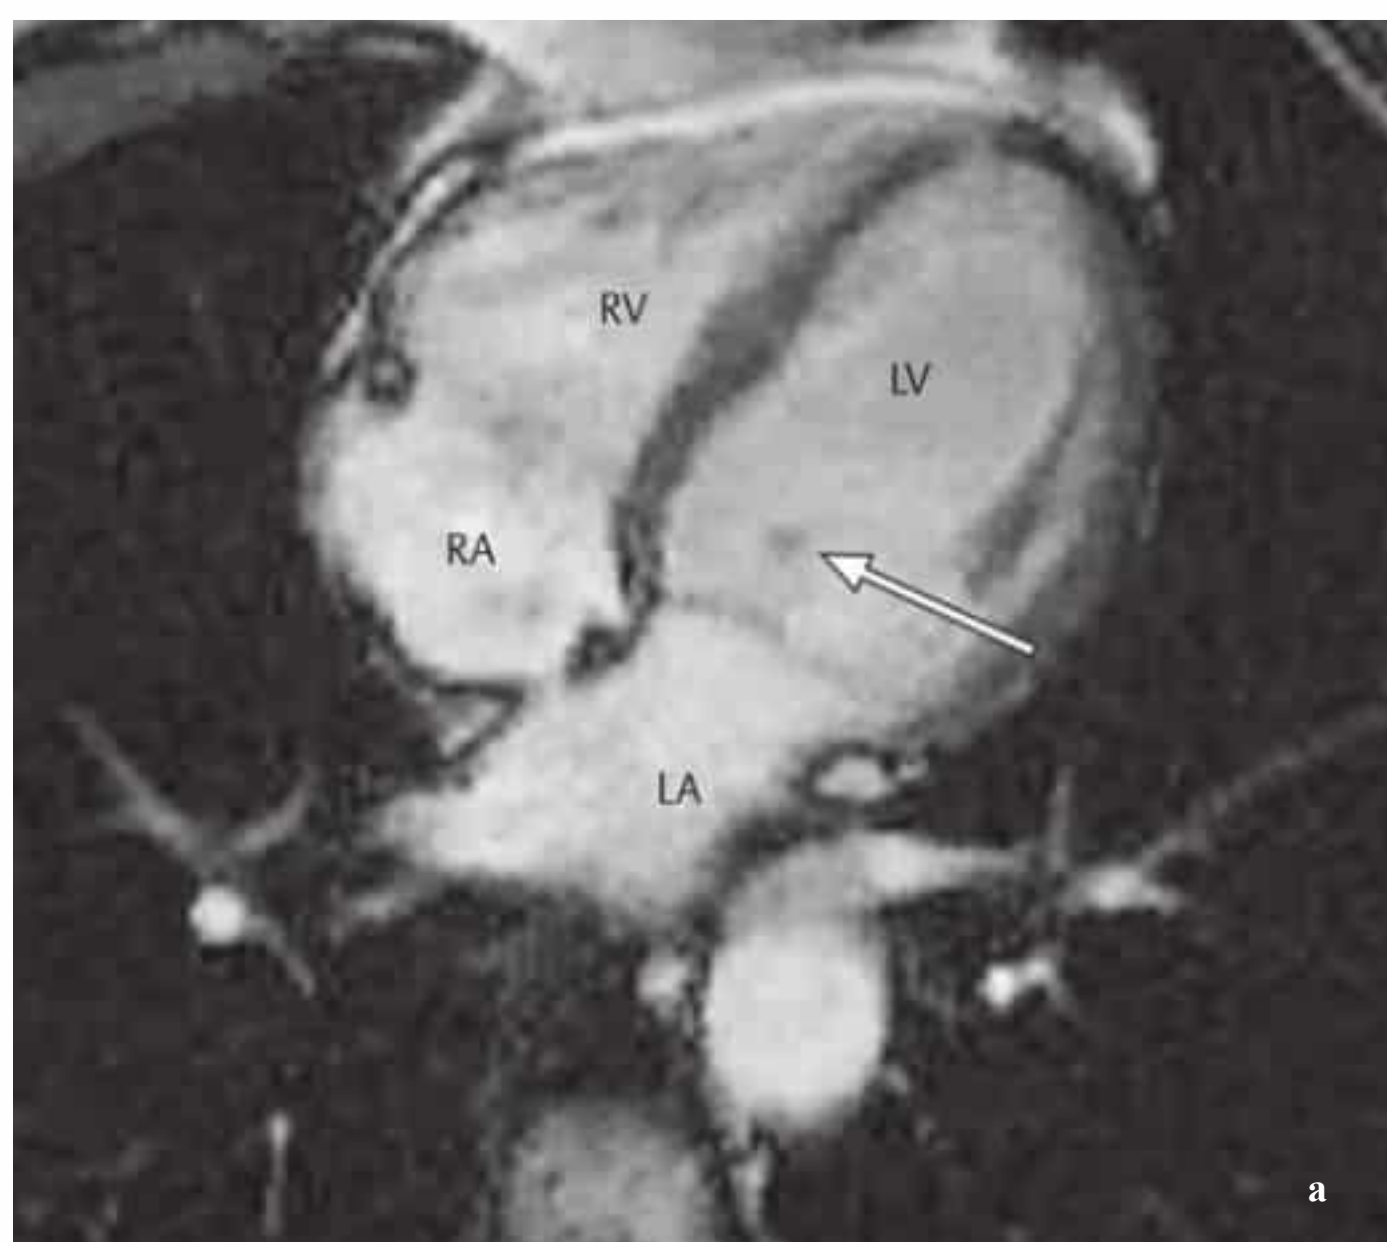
a–c Fibroelastoma 8 mm in diameter (arrow) on the chordae tendineae, located ~1 cm from the anterior mitral valve leaflet. SSFP cine sequence in the four-chamber view (a). The fibroelastoma is hyperintense on the T2-weighted image (b) and enhances markedly after contrast administration (c).
